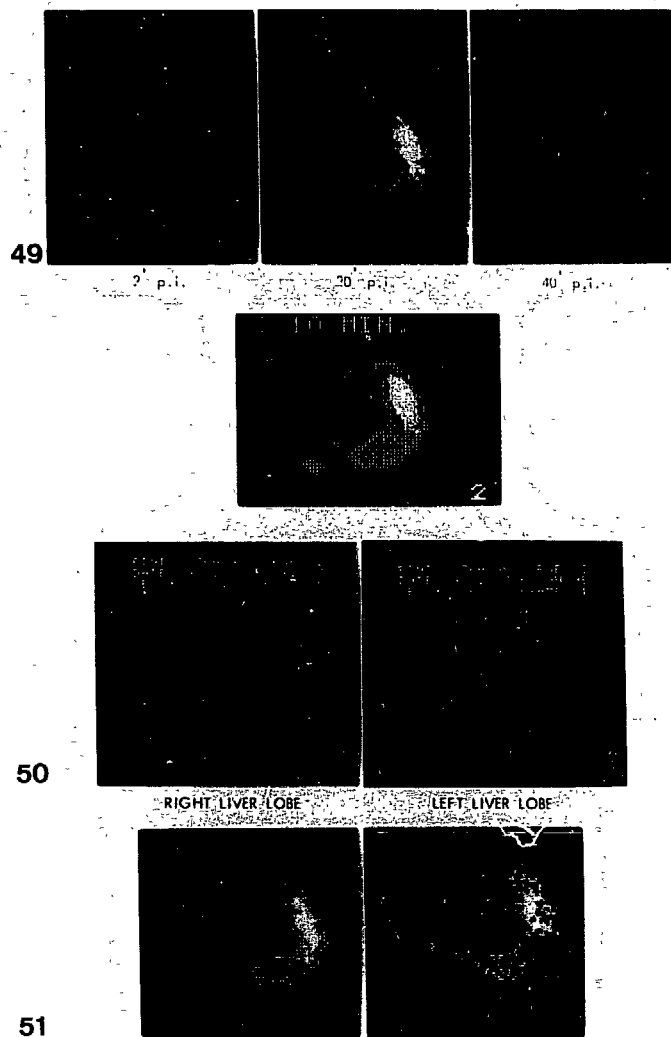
49-51 Cholescintigraphy in a patient with liver metastases.
